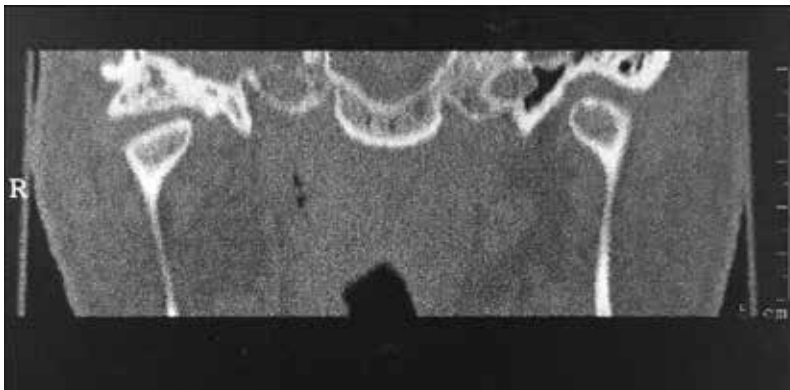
CT scan showing a mass in the right glenoid fossa dislocating the mandibular condyle.
